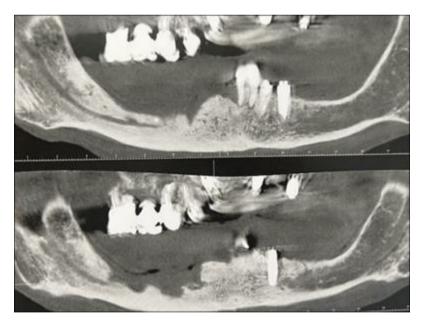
CBCT panoramic reconstruction showing the extensive bone necrosis of posterior and lateral right mandibular region with encroachment of the mandibular canal and perforation of the cortical bone plate
